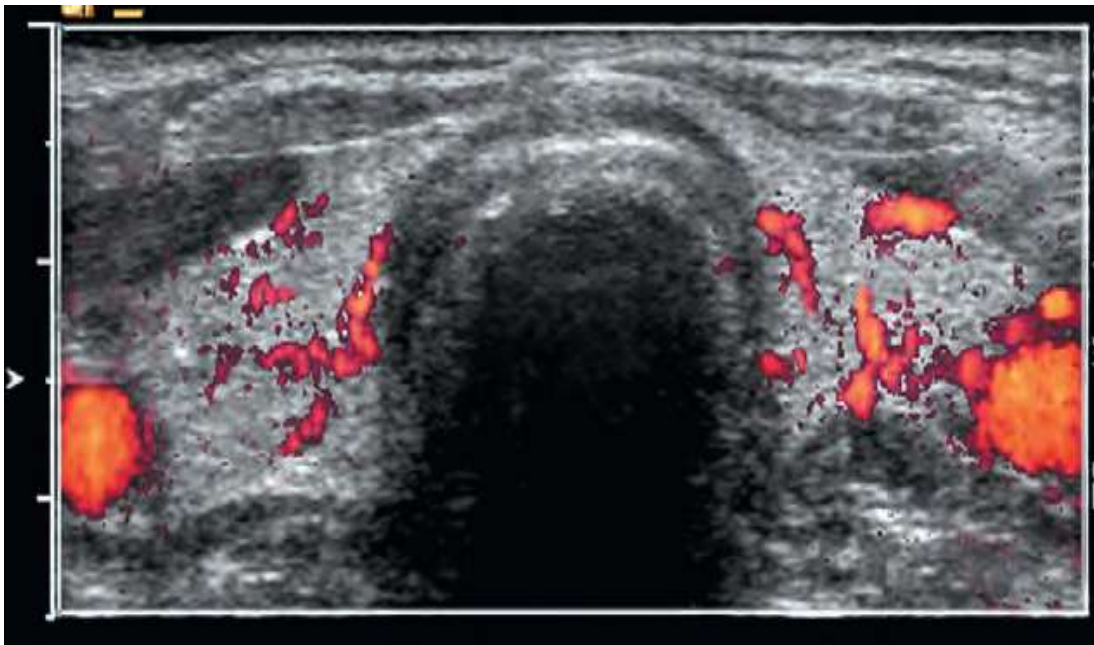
Normal thyroid gland with power doppler
